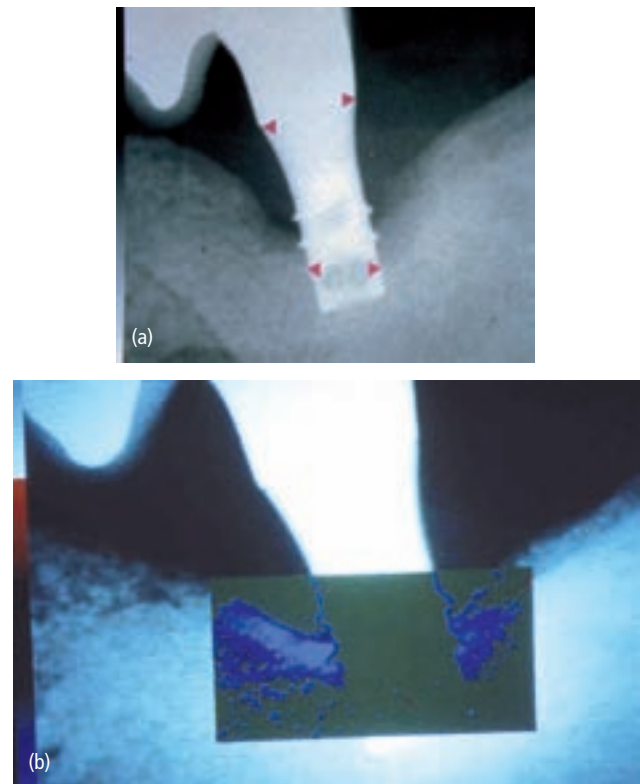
Cumulative interceptive supportive therapy (CIST) – regimens A+B+C+D: mechanical, antiseptic cleaning, administration of systemic antibiotics plus regenerative surgical therapy. (a) Baseline radiograph of a peri-implantitis lesion extending to the apical 2 mm of a hollow screw implant. Red arrows indicate the extent of the lesion from the crown implant level (approximately 5–6 mm bone loss). (b) Subtraction radiographic image 1 year after treatment documenting approximately 3–4 mm of bone fill (blue: increase in radiographic density). (Adapted from Lehmann *et al.* (66).)
